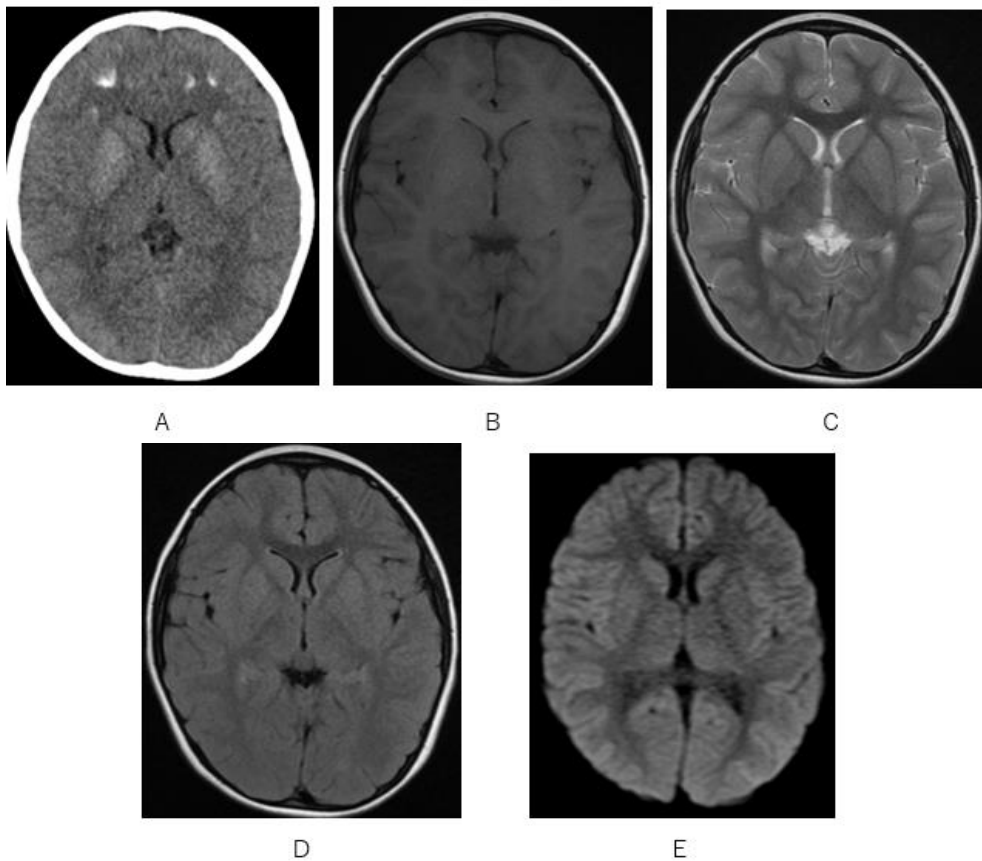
High and slight attenuation areas visualized on CT (A) are not demonstrated on T1WIMRI (B), T2WIMRI (C), FLAIRMRI (D), Diffusion WI (E).
